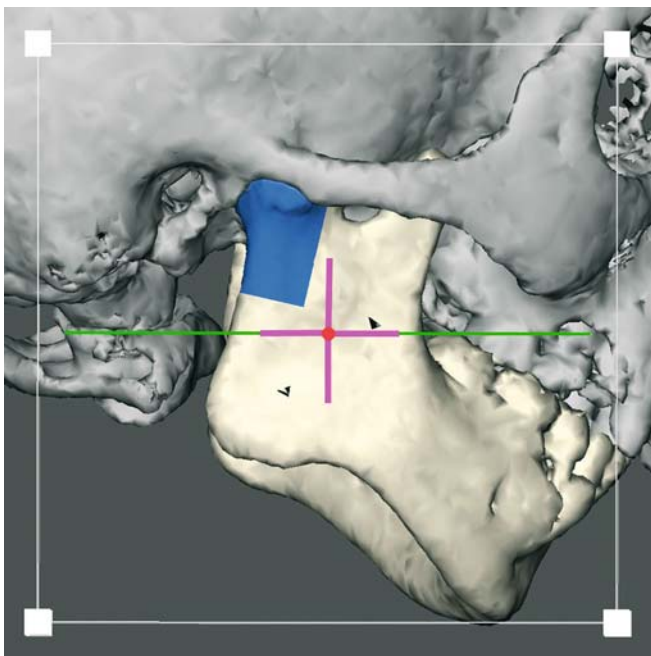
Virtual planning of a reverse L-osteotomy of the right vertical mandibular ramus. The position of the lingula (15 mm anterior to the posterior border of the vertical mandibular ramus and 19 mm inferior to the mandibular notch) is marked on the buccal cortex of the right vertical mandibular ramus. The reverse-L osteotomy is planned 10 mm anterior and parallel to the posterior border of the vertical mandibular ramus and 15 mm inferior to the mandibular notch in order to avoid nerve lesion. Profile view right. (3-D CT hard tissue surface representation, patient B.R.)
